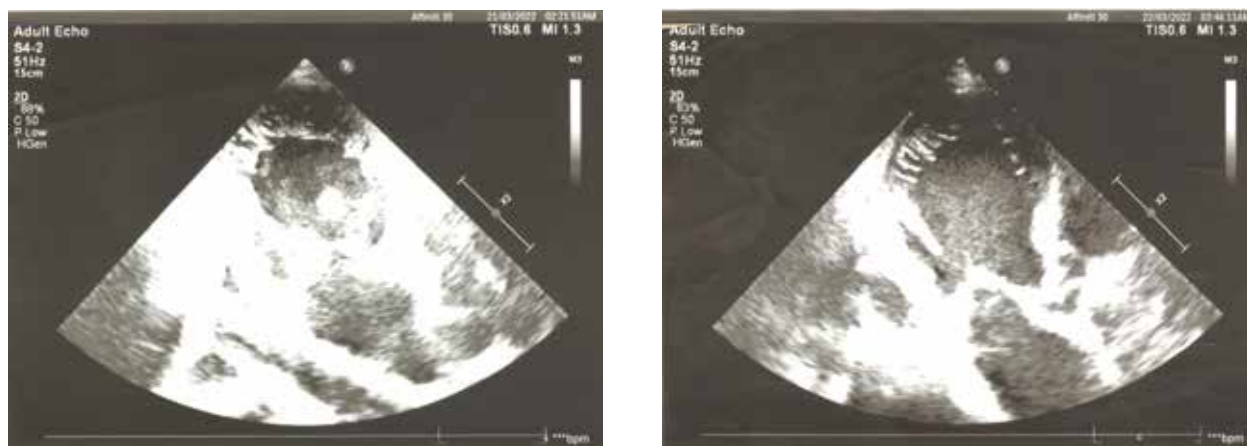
Transthoracic echocardiography. The presence of increased left ventricle trabeculation with deep recesses; noncompacted to compacted ratio greater than 2:1
